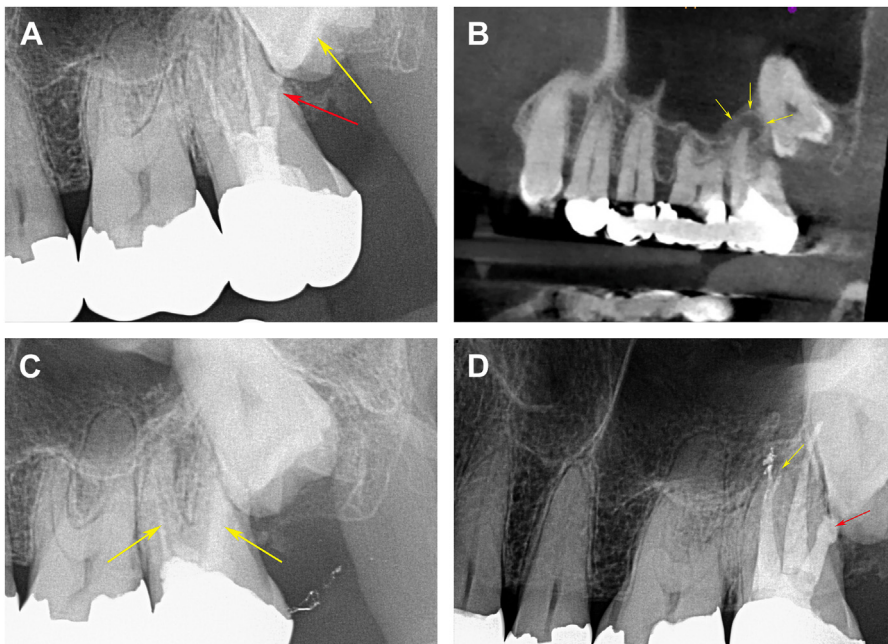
Failing previous RCT on a maxillary second molar with a periapical abscess and external root resorption. (A) Preoperative periapical radiograph showing external resorption of the distobuccal root (red arrow) due to an impacted third molar (yellow arrow) (B) CBCT showing the periapical radiolucency at the mesiobuccal root apex (yellow arrows). (C) Periapical radiograph after the first visit showing removal of the previous root filling and placement of intracanal calcium hydroxide (yellow arrows). (D) Immediate post-RCT radiograph showing a filled, previously missed MB2 canal system (yellow arrow) and the resorbed distobuccal root filled with a bioceramic filling (red arrow).
